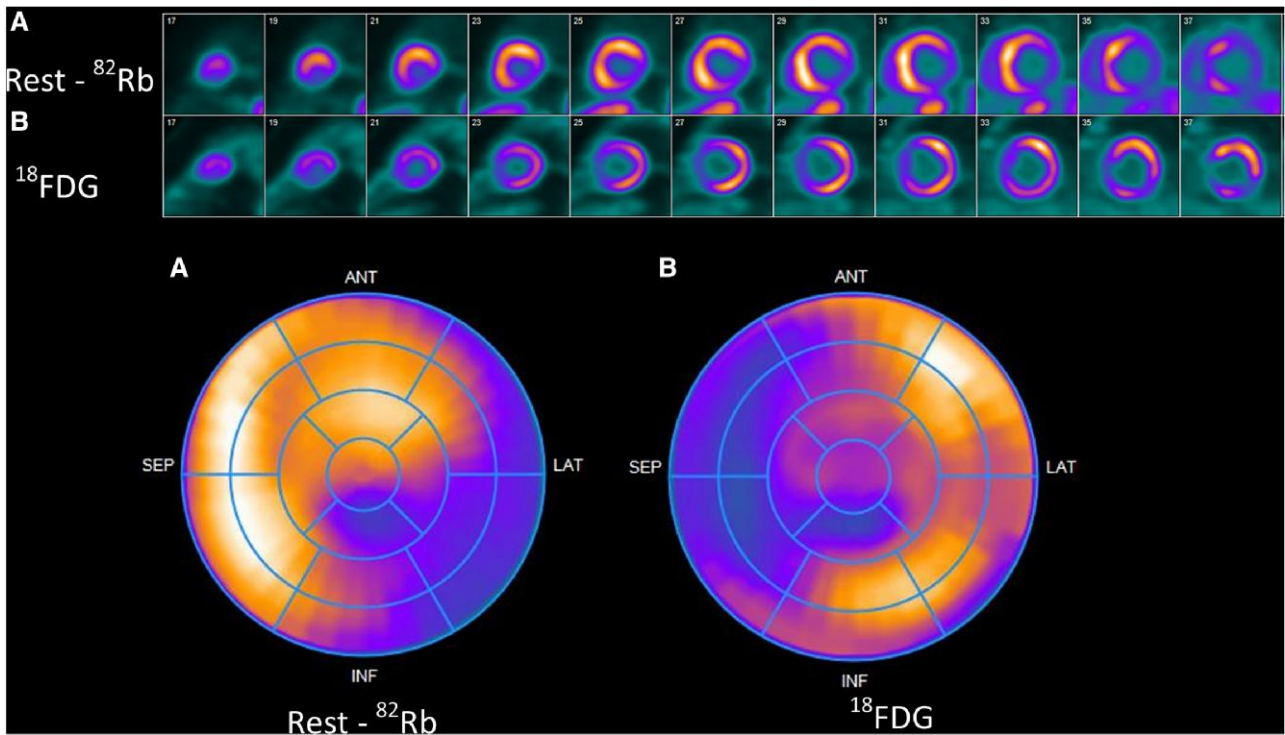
(A) Large fixed perfusion defect in the inferior and inferolateral segments on resting ^{82}Rb -chloride imaging. (B) Viability imaging shows FDG uptake in the inferior and inferolateral wall demonstrating hibernating myocardium.
